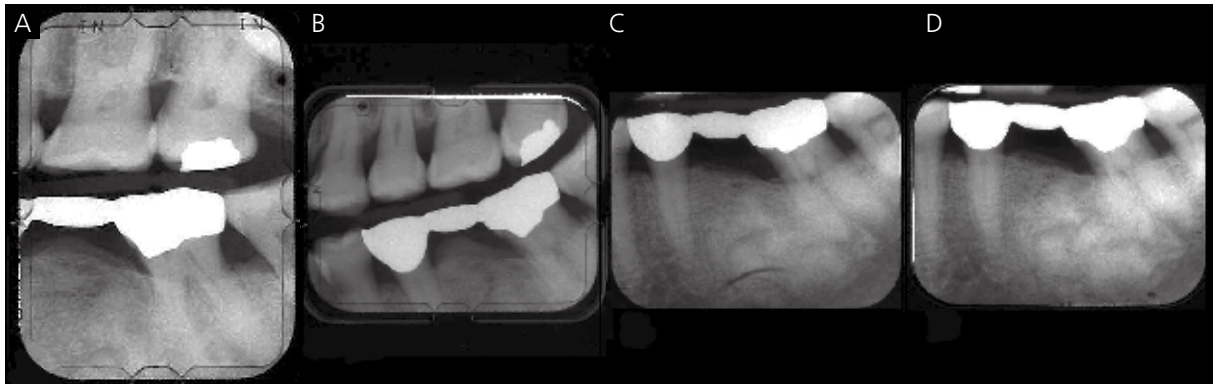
(Case No. 3) Periapical radiographic images of the FPD. A. Three years prior to initial visit. B. At initial visit (note the increase in lesion dimensions and the increased proportion of the radiopaque, cortical bone-like, coronal aspect of the lesion, which corresponds with Fig. 5B). C. Nine months postoperative. D. Eighteen months postoperative, which corresponds with Fig. 5F (note the mixed radiolucent/opaque area of alveolar bone, consistent with focal cemento-osseous dysplasia).
